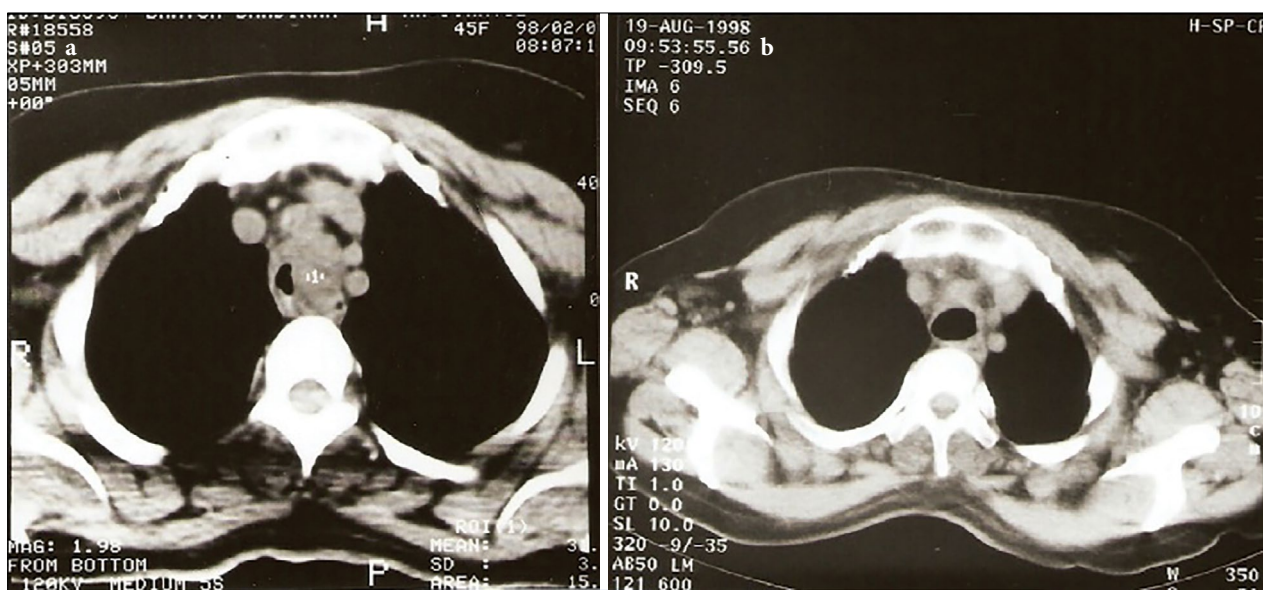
Complete response in a patient treated with curative chemo-RT. (a) Thorax CT shows a tumor that narrows the trachea. (b) Thorax CT shows complete response at 4 months with 66.6 Gy RT and concurrent weekly cisplatin in same patient.
